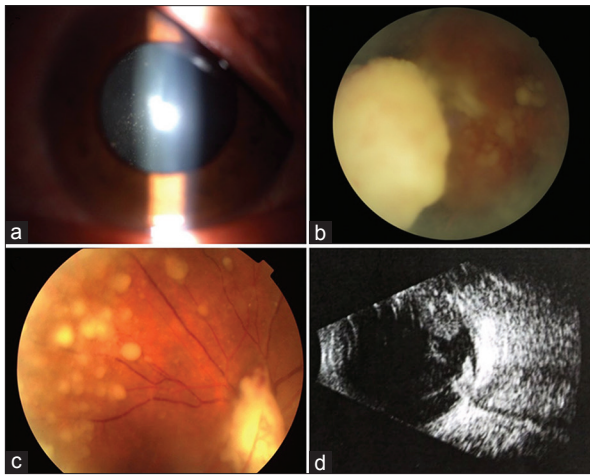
Slit-lamp examination showed plenty of small white floaters in the vitreous (a). Fundus examination showed large, whitish, elevated mass lesion in the inferonasal quadrant of the retina (b). Fundus examination showed whitish, elevated mass lesion with vascularization on the disk, with retinal seedlings of whitish, nodular lesions (c) B-scan ultrasonography showed vitreous opacities and intraocular elevated lesions and absence of calcification (d).
